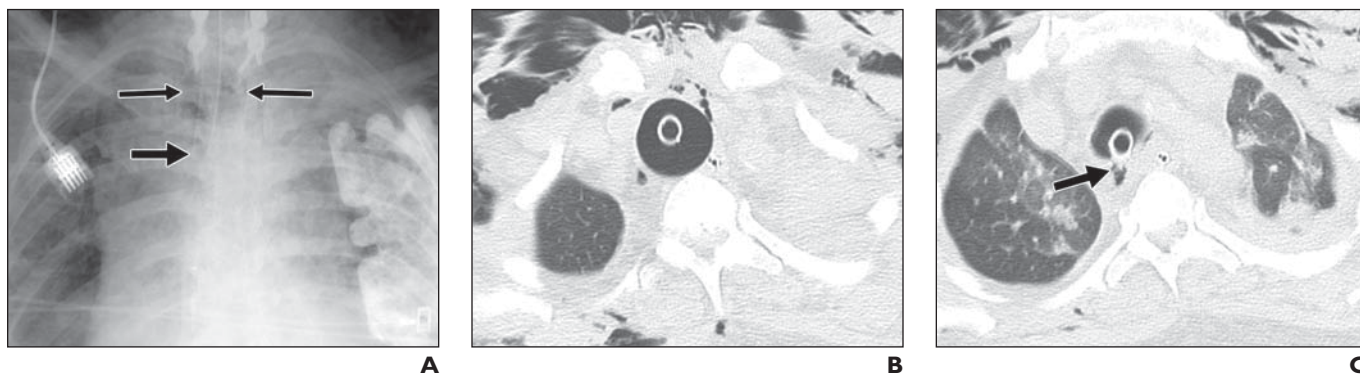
42-year-old man with tracheal rupture. A, Magnified anteroposterior chest radiograph shows overdistension of endotracheal tube cuff (*thin arrows*). Note right oblique displacement of distal portion of endotracheal tube (*thick arrow*) and reduced balloon-to-tip distance. Pneumomediastinum and subcutaneous and intramuscular emphysema are present. External pacemaker-defibrillator electrode plate is seen overlying left hemithorax. B and C, Sequential CT images show overdistension of cuff (B) and tracheal rupture (*arrow*, C).
